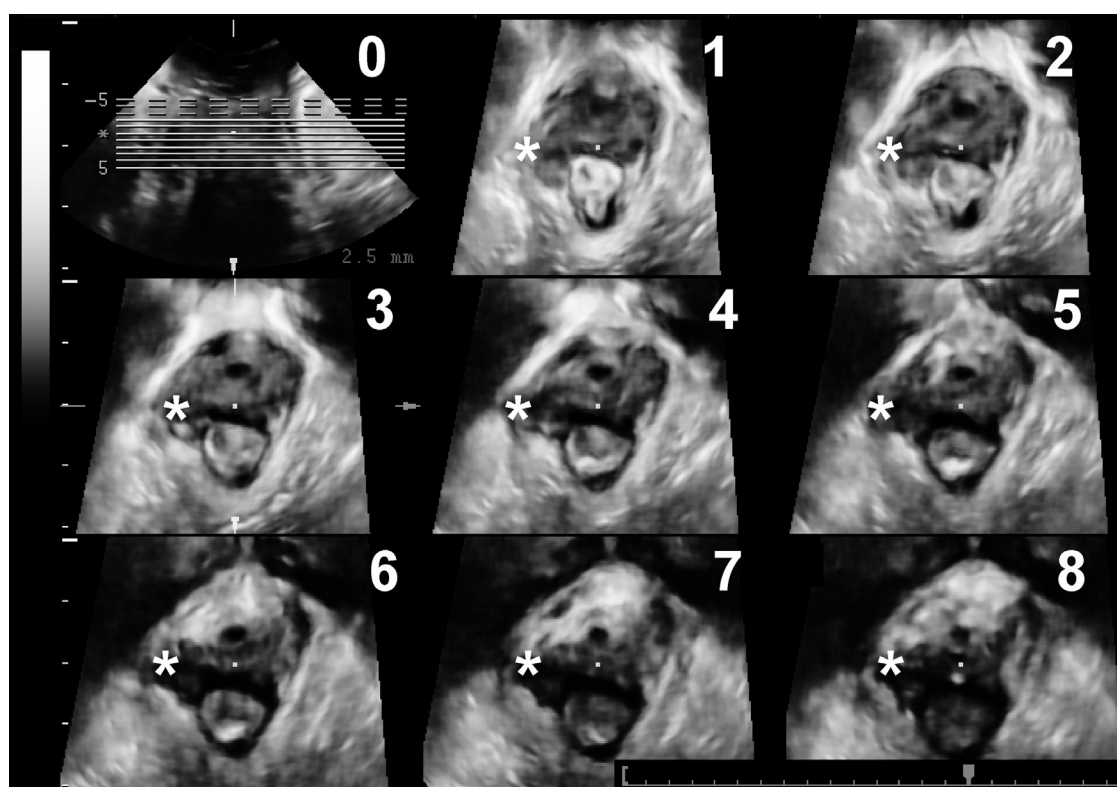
Tomographic ultrasound imaging of the entire puborectalis muscle. The * demonstrates a right-sided levator avulsion. Reproduced, with permission, from Dietz [16].
